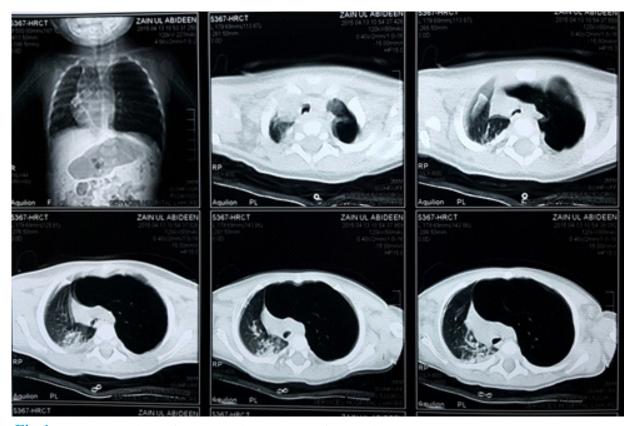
HRCT scan chest of patient with congenital lobar emphysema.
